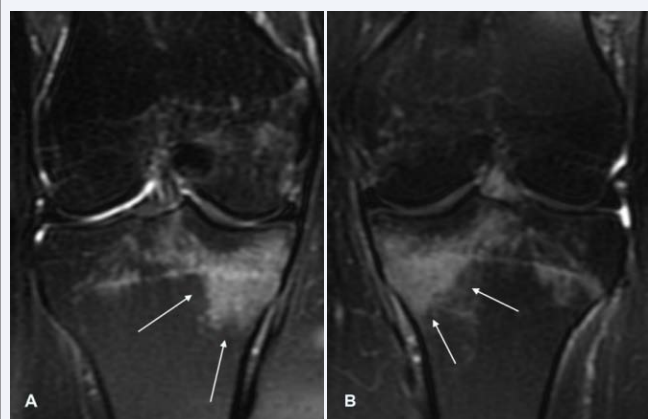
Coronal fat-suppressed T2-weighted images of right (A) and left (B) knee show bone marrow edema in the both side of medial tibial (arrows) plateau consistent with stress reaction.
